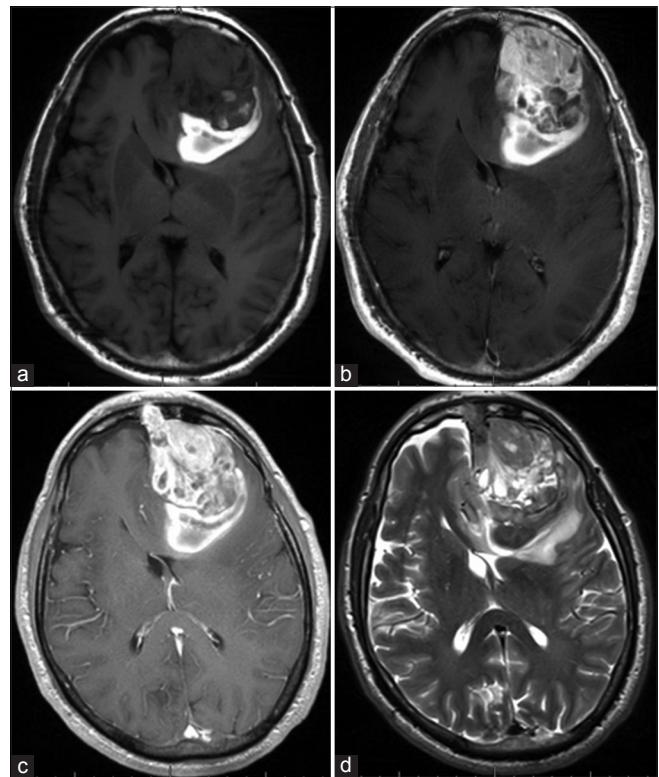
MRI brain. (a) T1 noncontrast and (b) T1 postcontrast sequences demonstrate a 7.0 cm×5.0 cm×4.9 cm heterogeneously enhancing left frontal mass with T1 shortening at the posterior aspect of the lesion, suggestive of prior hemorrhage. (c) T1 postcontrast sequences also reveal a dural tail and (d) T2-weighted sequences demonstrate a partial cerebrospinal fluid cleft around the periphery of the lesion; both findings suggest that the mass is extra-axial in origin.
